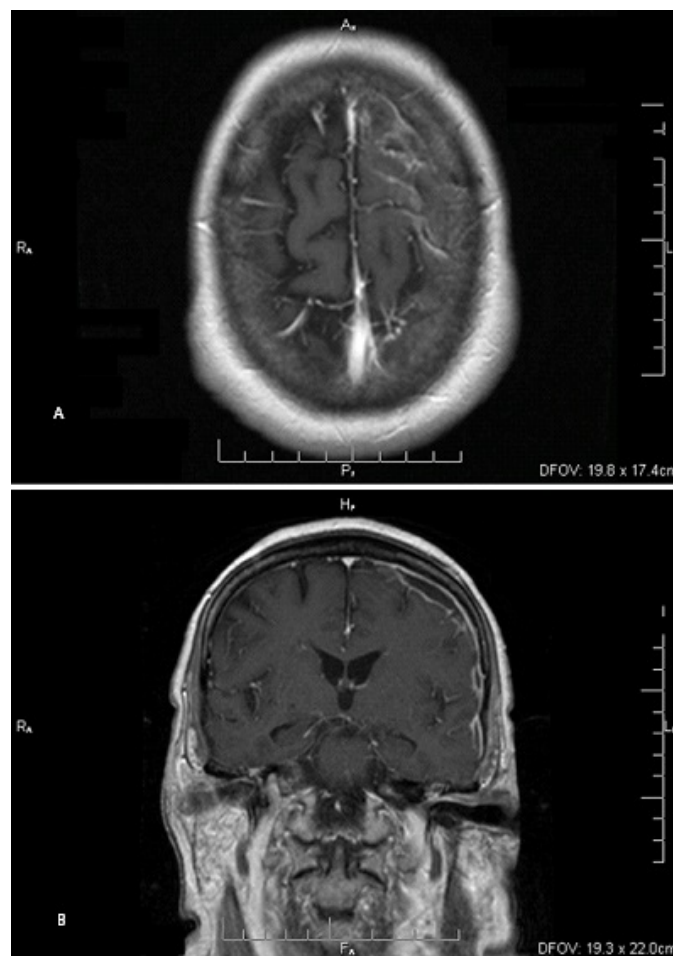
An MRI of the patient's brain with IV contrast with axial T1 image (A) and coronal (B) images showing progressed proteinaceous fluid in the left frontal and parietal sulci, with associated mild enhancement and some focal areas of restricted diffusion and overlying subdural collection. Full mastoid air cells are also visible bilaterally (right greater than left) inferior to each ear canal (B).
